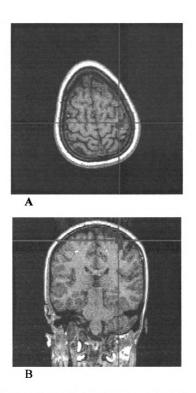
Anatomical 3DSPGR MRI image of the human brain
